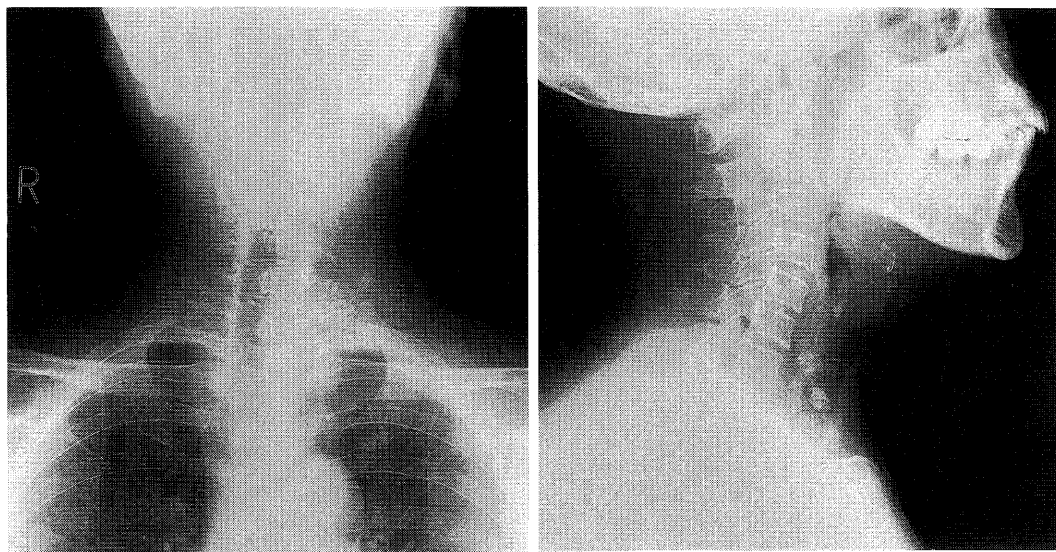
Anterior and lateral radiographs of the neck show coarse calcifications in the left neck and tracheal deviation to the right.
